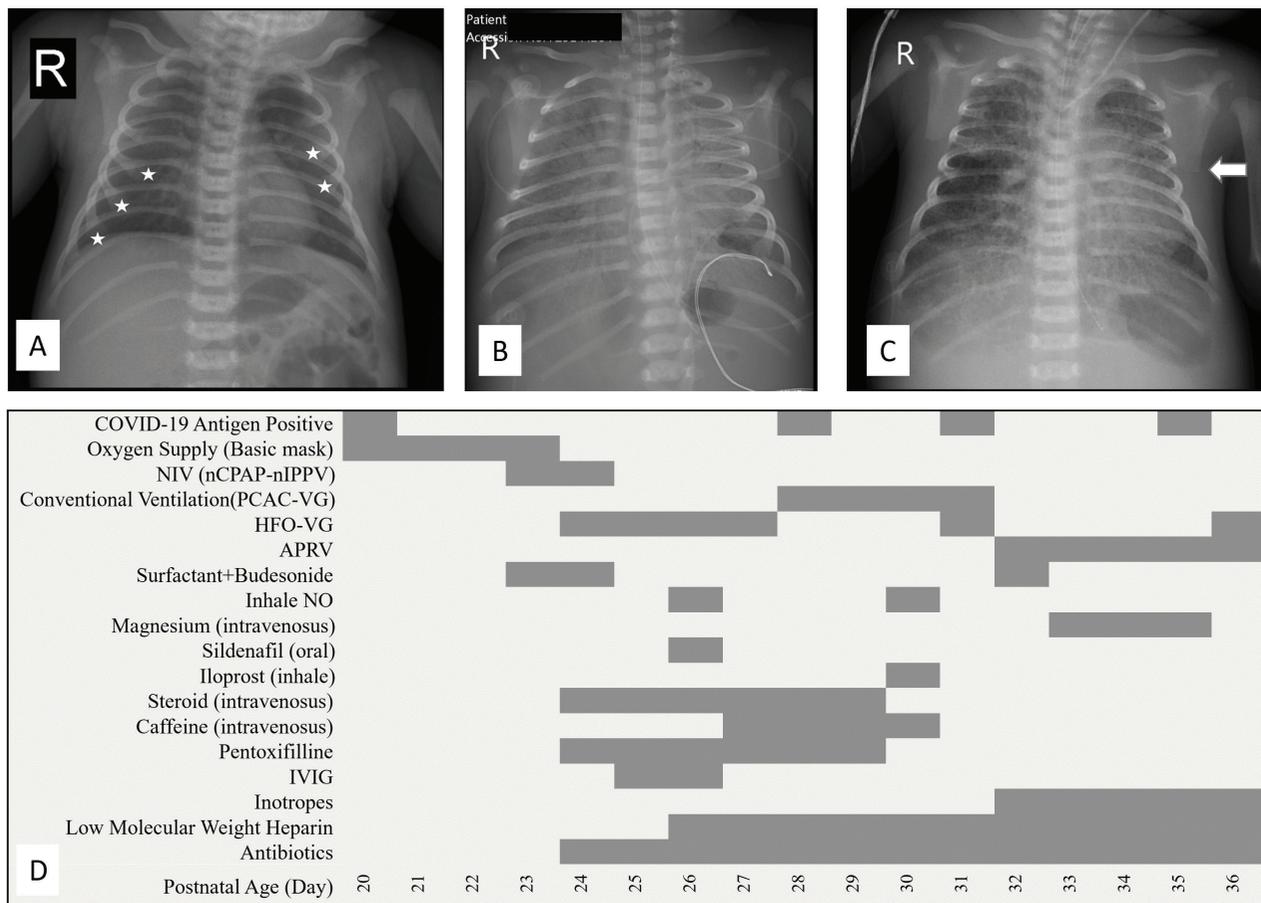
A: Initial chest X-ray of Case 2 (stars: cupping of costochondral junctions); B: Chest X-ray of case 2 at the time of NARDS diagnosis; C: Chest X-ray of case 2 on follow-up (arrow: squaring of the inferior scapular angle); D: Treatment regimen of case 2
